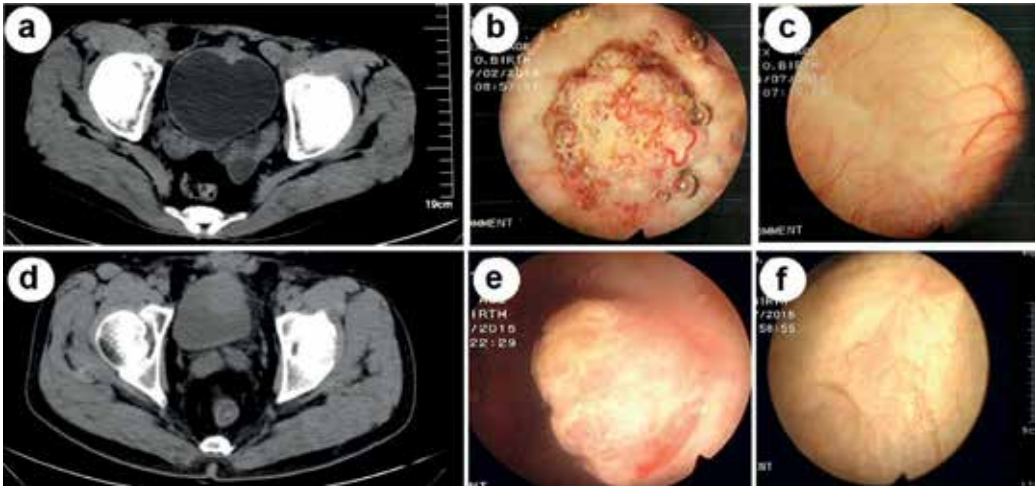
Representative images of CT scans and cystoscopies. a–c Images of pelvic CT scan and cystoscopies before and after the surgery (patient 1, the tumour was located at the superior wall with the size of 24 × 22 cm). d–f Images of pelvic CT scan and cystoscopies before and after the surgery (patient 2, the tumour was located at the superior wall with the size of 28 × 17 cm).
